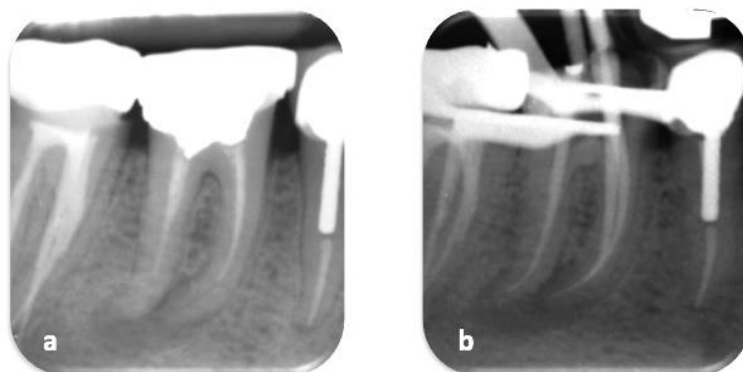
PA radiographs of tooth 46 (a) Pre-operative (b) Master cone 36 (c) Postoperative.
